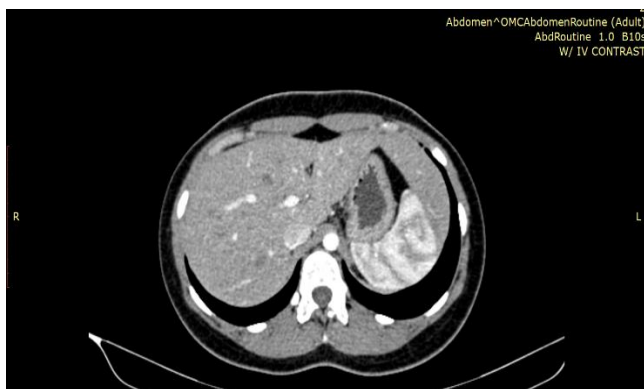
14 years old female - Axial enhanced CT scan of the abdomen (arterial phase), the spleen is showing a significant mottled early arterial enhancement that make it much more differentiated than the adjacent hepatic tissue.
